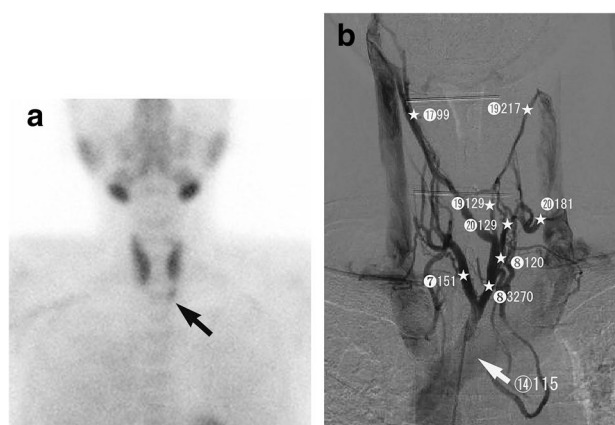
A 35-year-old male with inconsistent imaging findings (same case as shown in Figs. 1, 2, 3). a ^{99m}Tc-MIBI scintigram demonstrates suspicious accumulation inferior to the left lobe of thyroid gland (*arrow*). US does not show a suspicious lesion (not shown). b, c The iPTH value is increased in the proximal left inferior vein (8; 3270 pg/ml) compared with that in the distal portion (8; 120 pg/ml). The iPTH value is not elevated in the left brachiocephalic vein (14; 115). A suspicious lesion in the left inferior quadrant of the left lobe, consistent with the ^{99m}Tc-MIBI findings. A pathological parathyroid adenoma can be seen (*gray ellipse*)
